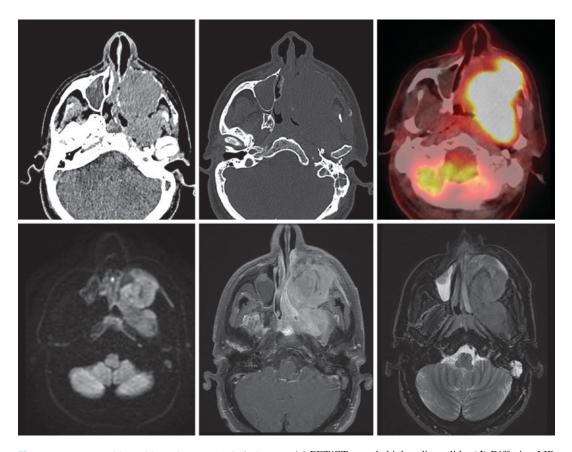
Mucoepidermoid carcinoma. (a) Soft tissue level CT reveals perforated cortical borders of a well-defined lesion with an ill-defined soft tissue extension to adjacent structures at the posterior region. (b) Bone level CT reveals destruction at maxillary sinus cortical borders.
